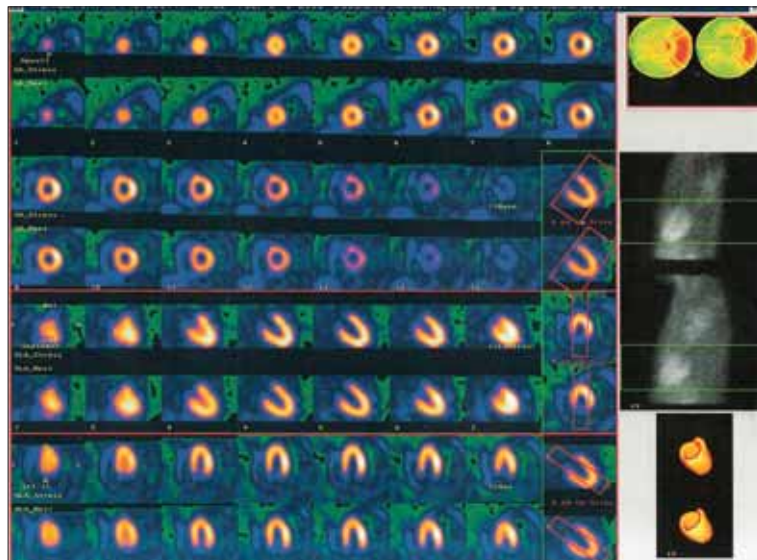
Stress/Rest Tc-99m Myoview perfusion SPECT using a bicycle ergometer shows no perfusion defects due to stress-induced myocardial ischemia.
